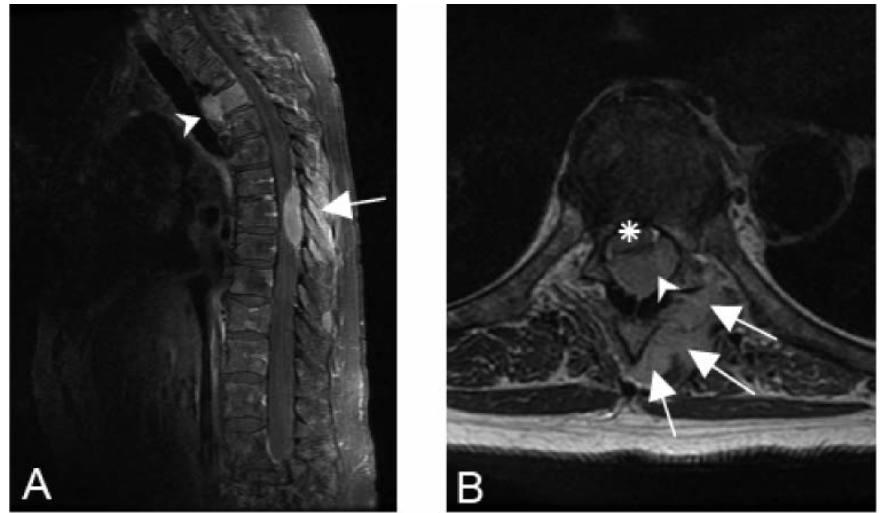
(A) Sagittal T1-weighted MRI with gadolinium reveals a homogeneously enhancing tumor in the posterior elements of T6 to T8 with epidural extension (arrow), and in the T4 vertebral body and prevertebral soft tissue (arrowhead). (B) Axial T1-weighted MRI with gadolinium shows severe compression of the spinal cord (asterisk) by the tumor (arrowhead) and tumor mass in the spinous process and paravertebral musculature (arrows).
